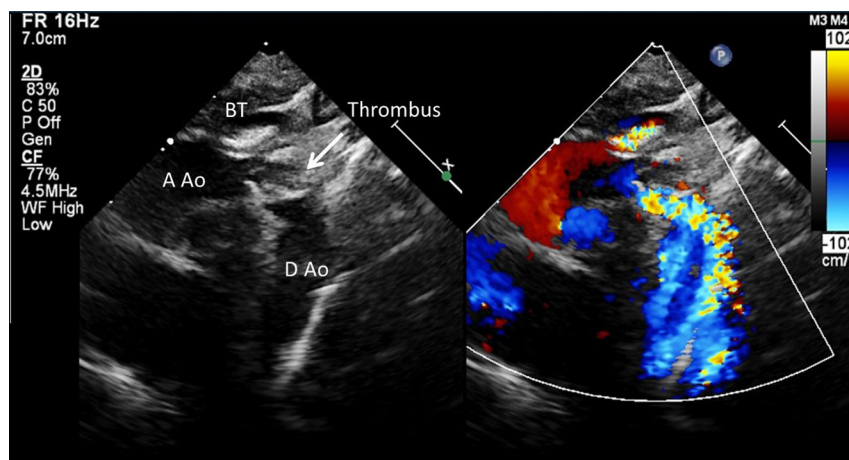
Preoperative echocardiography. A Ao, Ascending aorta; BT, brachiocephalic trunk; D Ao, descending aorta; arrow, thrombus located at the origin of the left carotid artery and left subclavian artery, without clear blood flow through these arteries. There was turbulent flow below the thrombus at the aortic cross level and turbulent flow at the brachiocephalic trunk (partially occluded).
